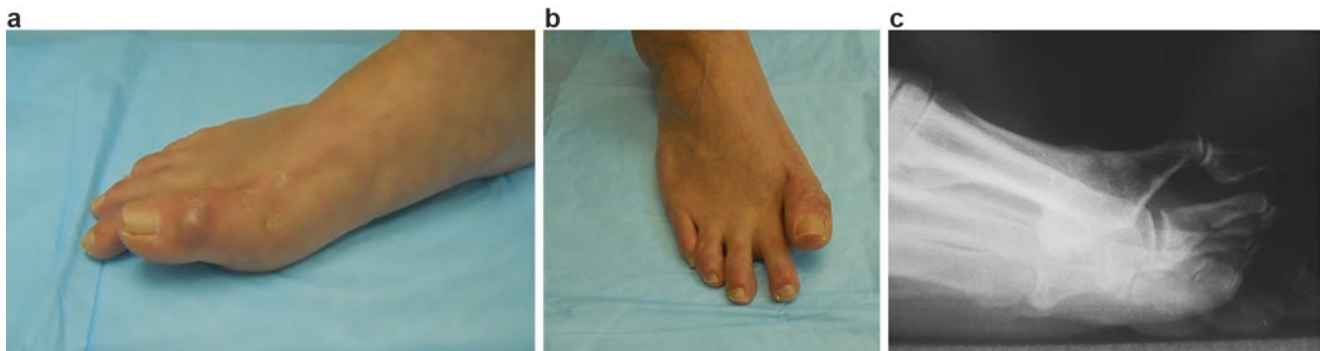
(a, b) Clinical example of a dorsiflexed malunion. (c) Lateral radiograph of a dorsiflexed malunion
